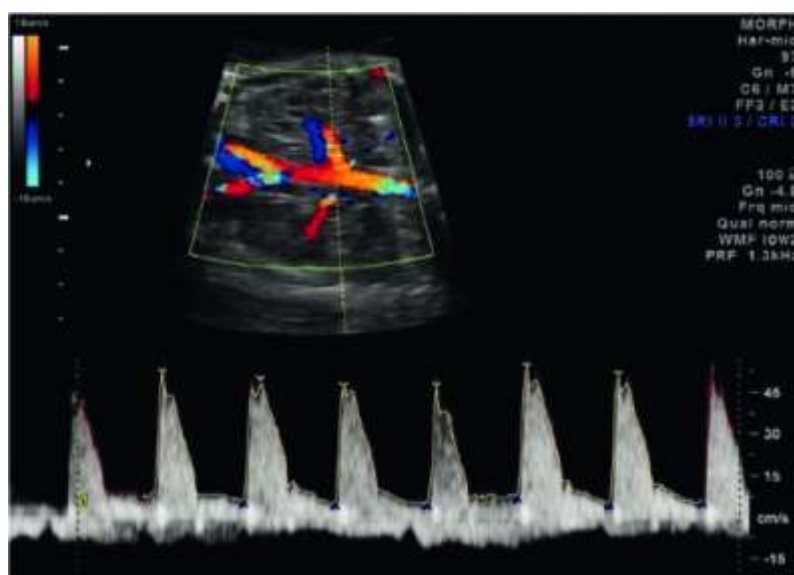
Fetal Renal Artery Doppler²
